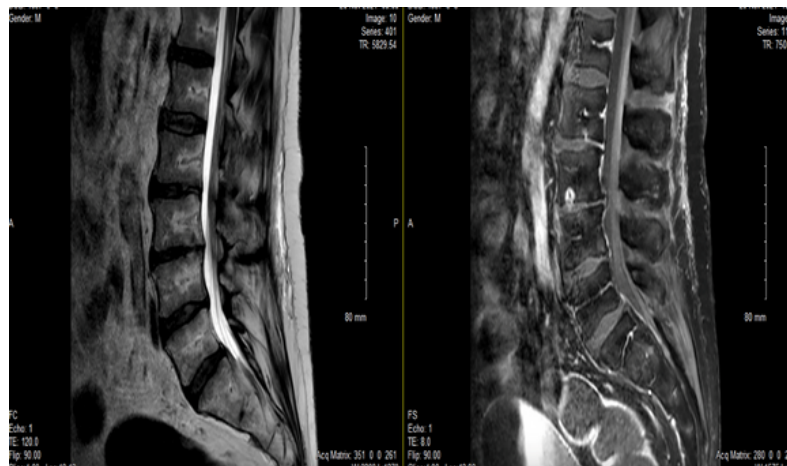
MRI L Spine w/wo (T2 sagittal, T1 post)
